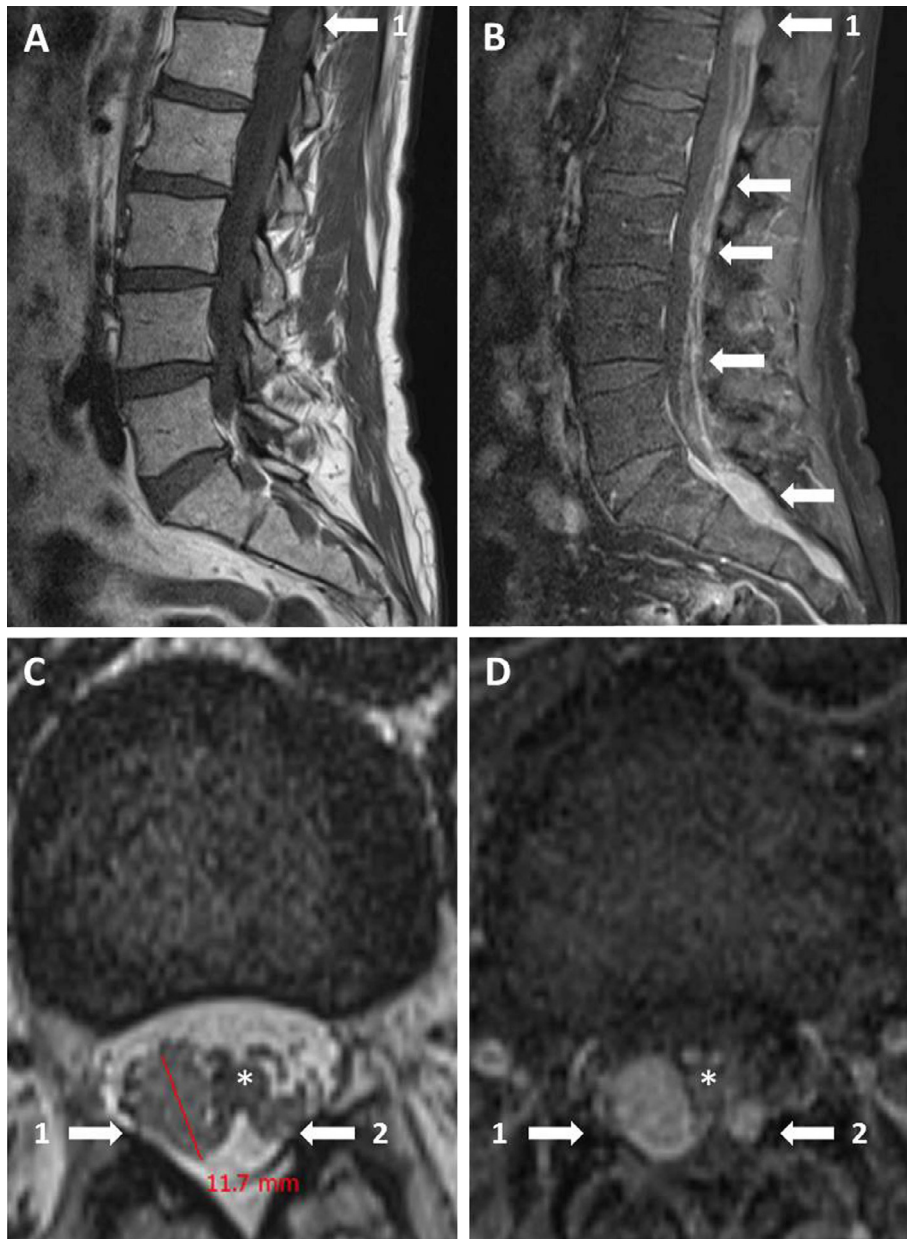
Nodular extra-medullary lesions along lumbosacral nerve roots (arrows) are enhanced by gadolinium injection (A: T1-weighted MRI; B: post-contrast T1-weighted-fat saturated MRI). The largest nodular lesion (1) causes direct compression of the conus medullaris (*), with another smaller contralateral nodular lesion (2) (C: axial lumbar T2-weighted MRI; D: axial lumbar post-contrast T1-weighted-fat saturated MRI).
